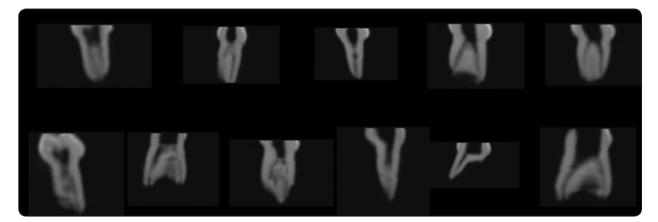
CBCT showing: type II mesial root lower D, type IV medial root lower, type I distal root lower D, type IV distal root lower D, type V distal root lower D, type IV mesiobuccal upper D, type VIII MB upper D, type I DB upper D, type I and type IV palatal upper D
